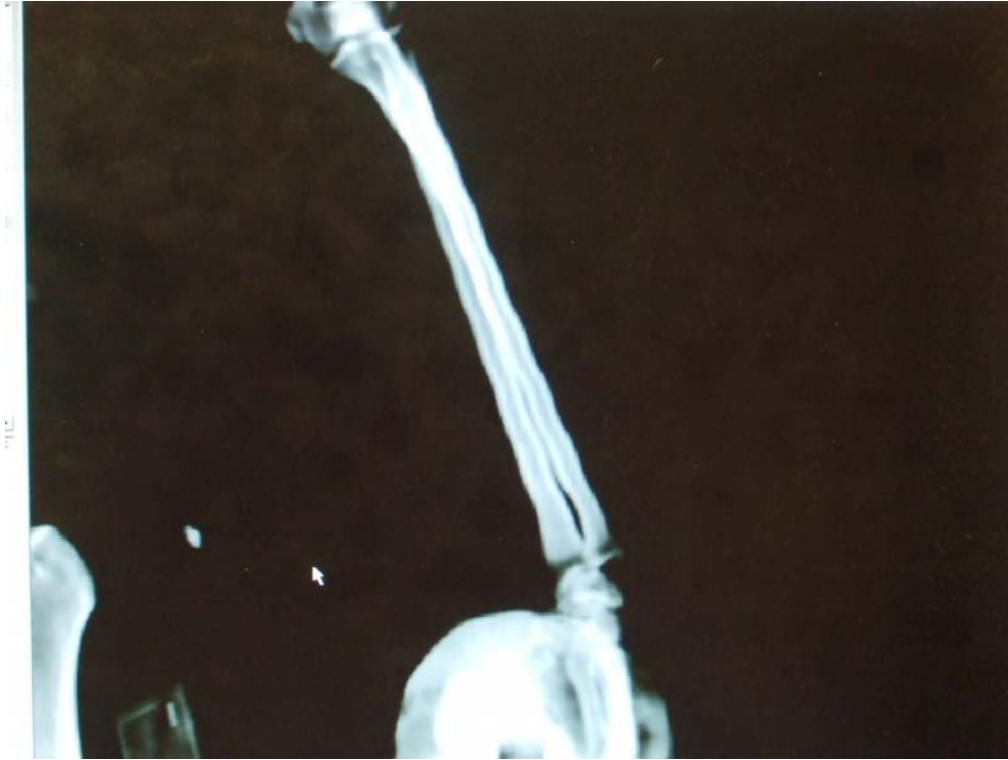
Coronal slice of an obliquely positioned arm acquired with high pitch helical CT produces wave like patterns in the structures of the arm.
